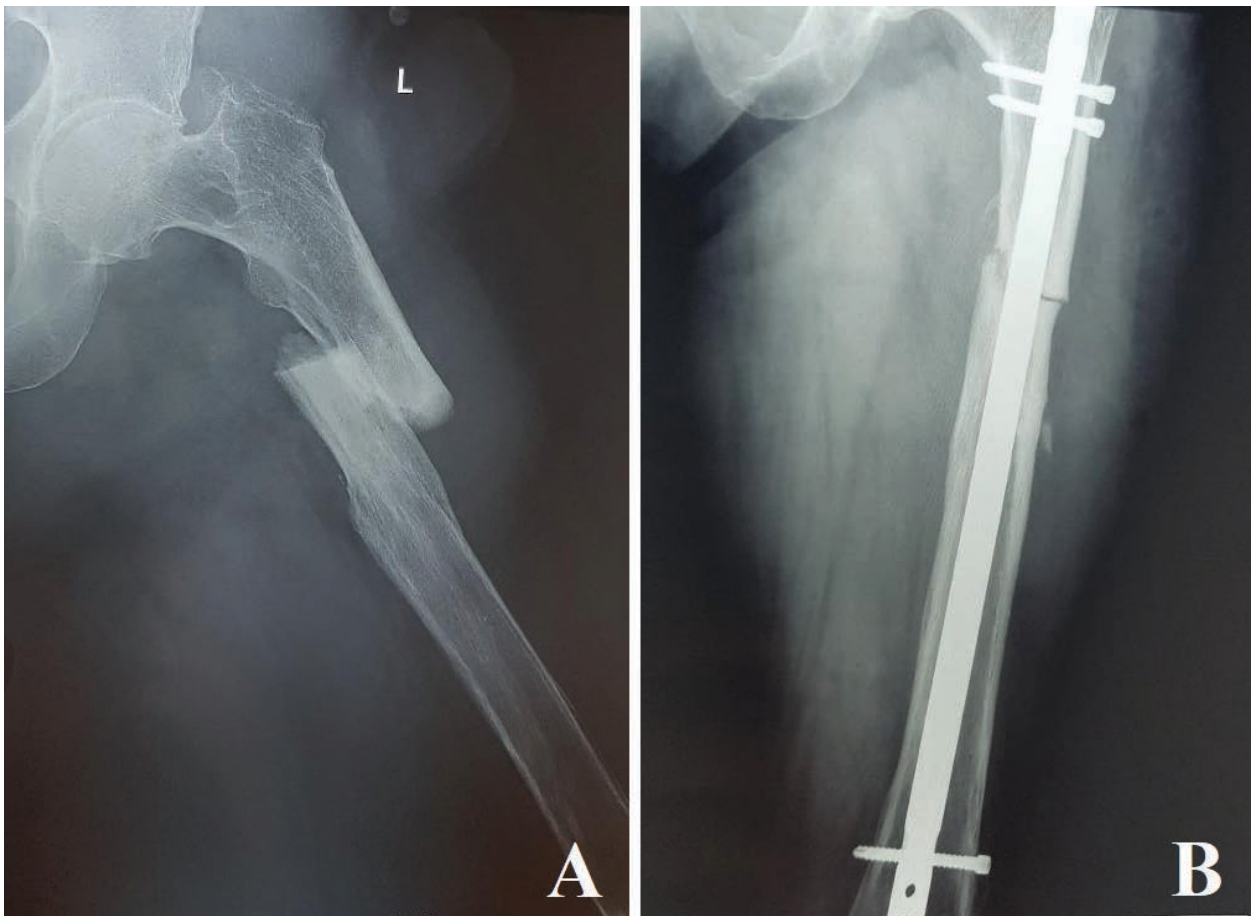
Left femoral shaft atypical fracture secondary to BPs therapy. (A) Preoperative aspect - X-ray view (anteroposterior incidence), (B) Postoperative aspect – intramedullary nail
